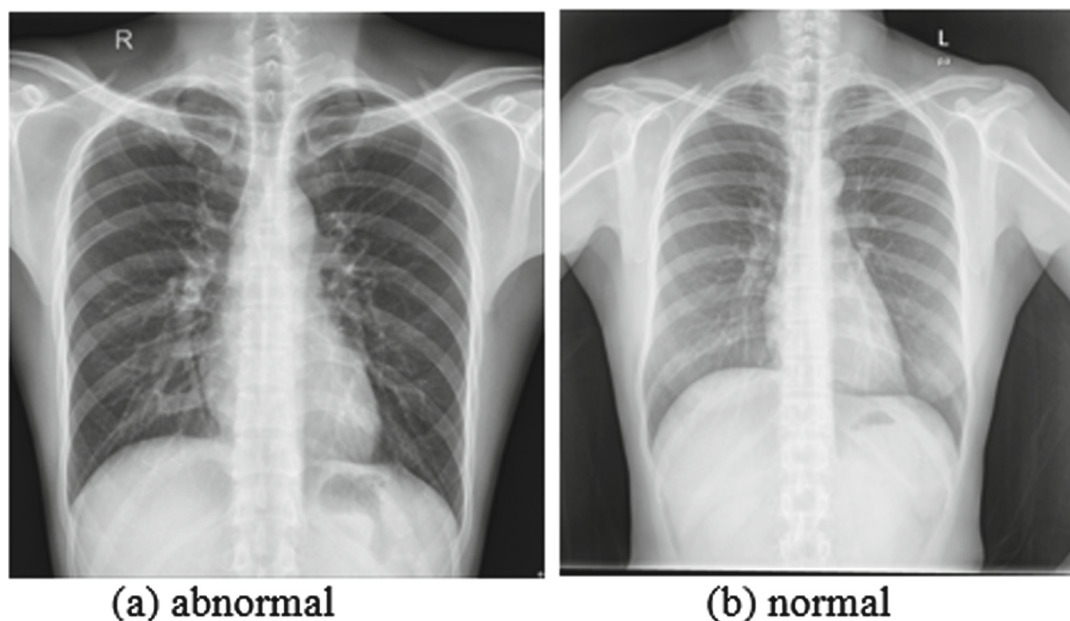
Sample of the normal and abnormal chest X-ray.
